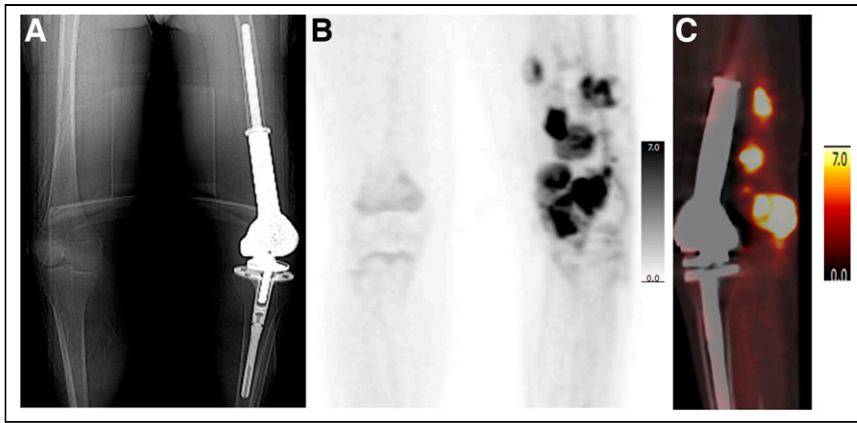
A 15-y-old boy with history of osteosarcoma in left femur and limb-sparing procedure on left lower extremity. (A) Topogram from attenuation-correction CT shows rotating-hinge modular prosthesis in left distal femur and left knee. (B) Anterior maximum-intensity projections shows multiple areas of markedly elevated uptake in left lower extremity. (C) PET/CT sagittal view of left leg shows numerous soft-tissue nodules with intense uptake posterior to prosthesis (SUV_{max} , 20.3).
